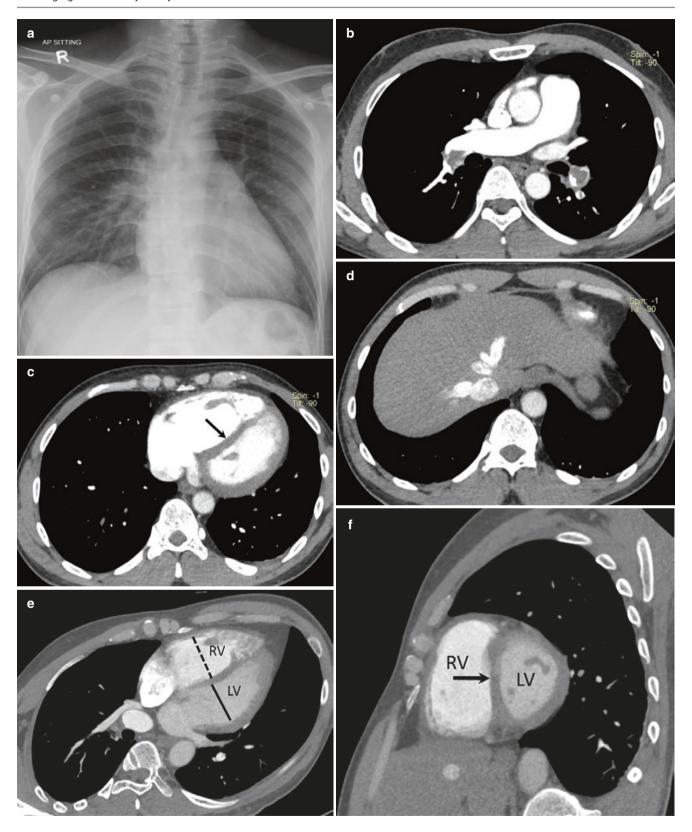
A 42-year-old man with acute PE and right ventricular dysfunction. (a) Chest radiograph shows oligemia in the left lower zone (Westermark sign). (b–d) Axial CTPA images show bilateral acute PEs, septal deviation (arrow), and reflux of contrast in IVC. (e)
